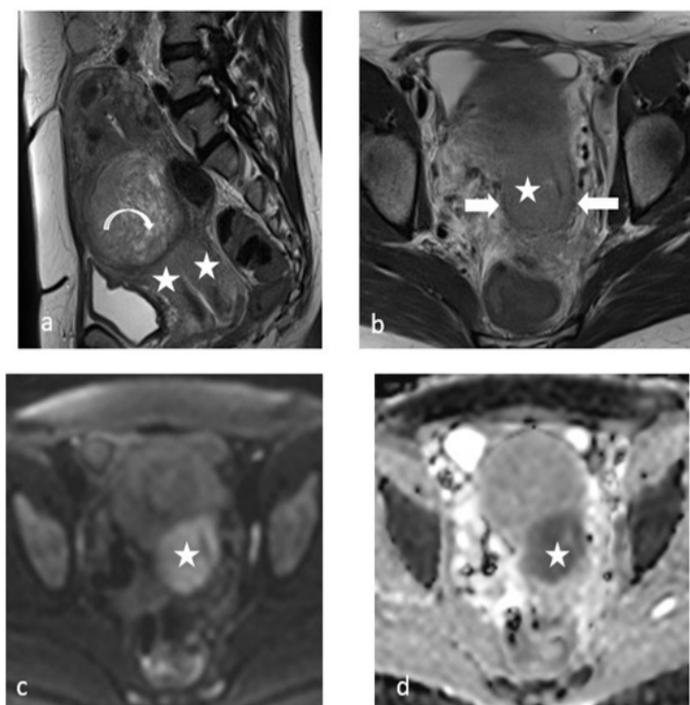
Sagittal T2 (a) and axial T2 (b) pelvic MRI sequences show cervical mass (asterisks) with parametrial invasion (arrows). Note a corporeal cellular myoma (curved arrow). The mass shows a hypersignal in diffusion sequence (c) (asterisks) with important restriction (d) (asterisks).
